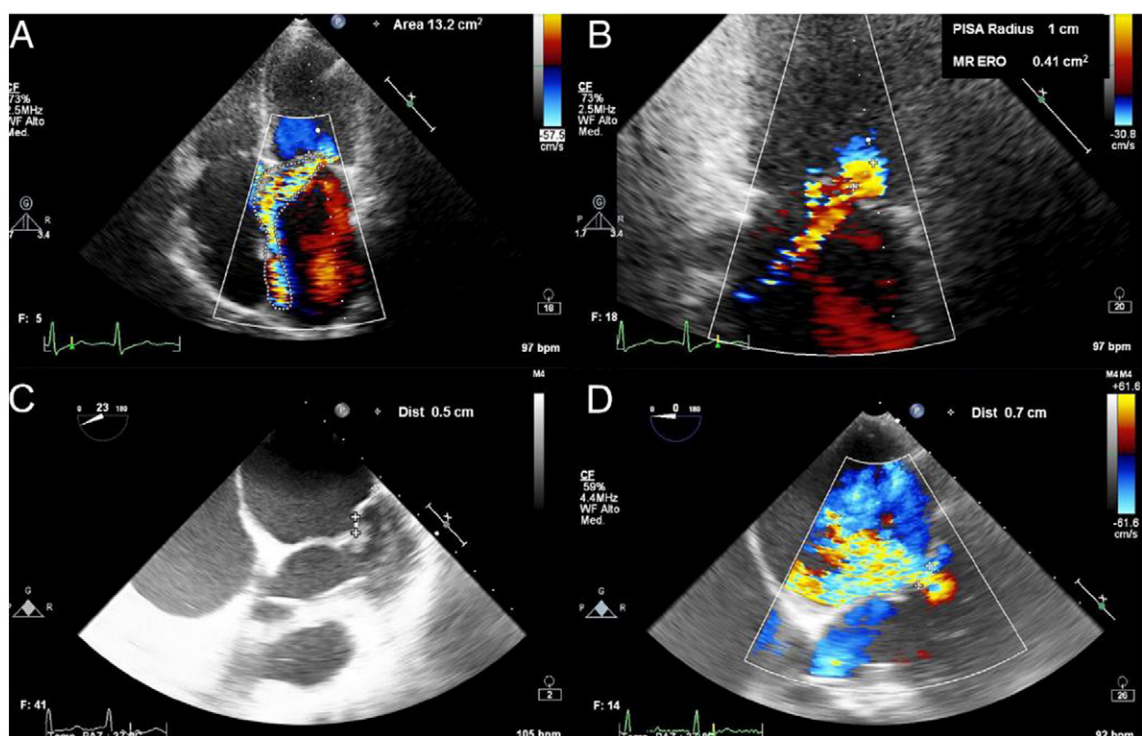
Transthoracic echocardiography showing a severe eccentric mitral regurgitation jet (panels A and B). The transesophageal study documented posterior mitral leaflet prolapse (P1–P2), with a flail gap of 0.5 cm (panel C) and confirmed the severity of mitral regurgitation (vena contracta of 0.7 cm at color Doppler, panel D). Panel E: three-dimensional echocardiography monitoring the position of the MitraClip above the mitral valve during the procedure. Panel F: mild residual mitral regurgitation after MitraClip implantation. ERO, effective regurgitant orifice, MR, mitral regurgitation, PISA, proximal isovelocity surface area.
